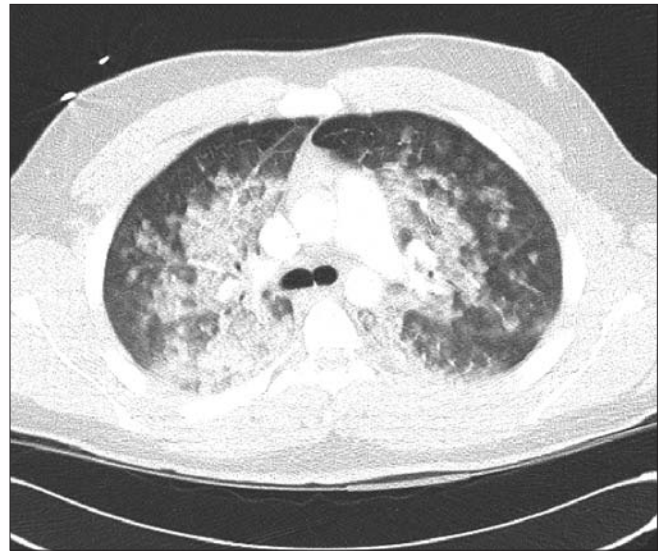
A contrast CT scan of the chest showing bilateral airspace disease.
